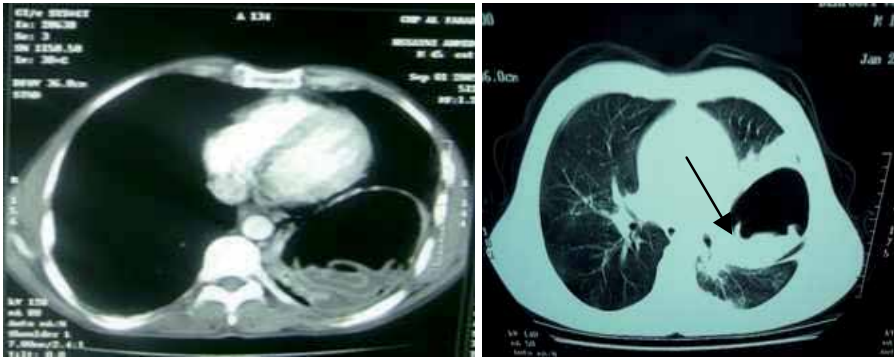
CT scan of thorax showing the torn germinal layer in the right hydatid cyst: the 'water-lily sign.'
